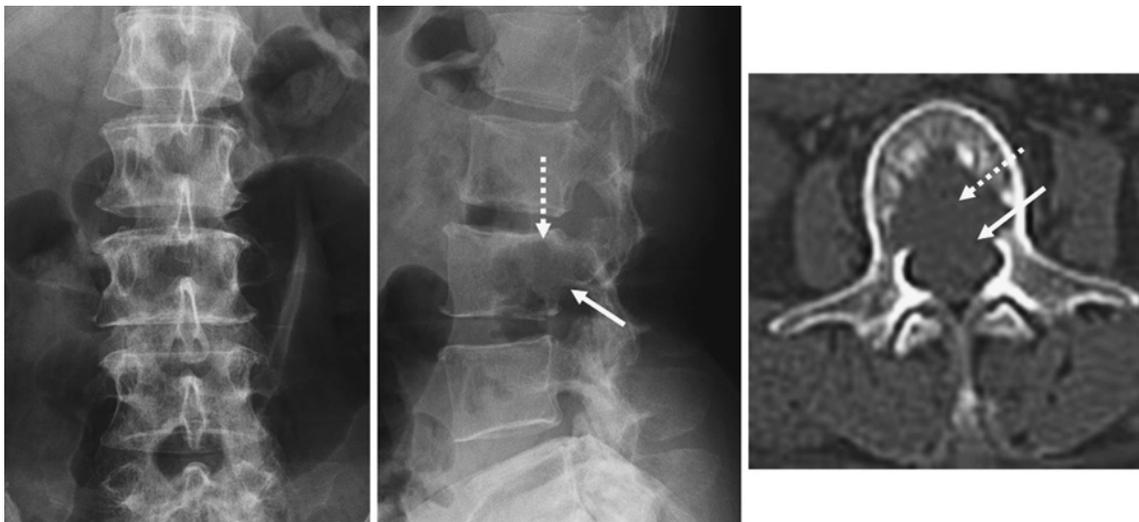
Radiographic imaging of a 63-year-old woman with third lumbar vertebra metastasis of thyroid cancer. Radiographs show the disappearance of the posterior cortex (arrow) and increased radiolucency of the central area in the vertebral body (dashed arrow). CT shows extensive destruction of the posterior part of the vertebral body (arrow) and posterior cortex (dashed arrow).
